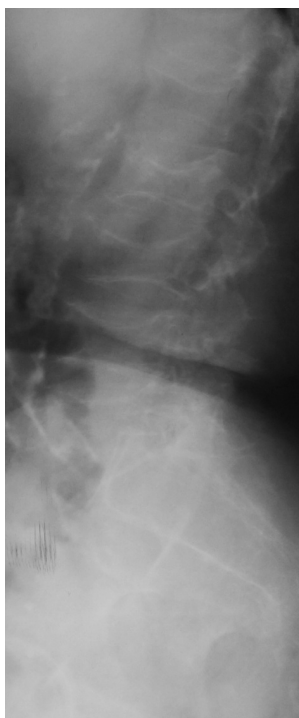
X-ray of lumbosacral spine with vertebral body compressive fracture
